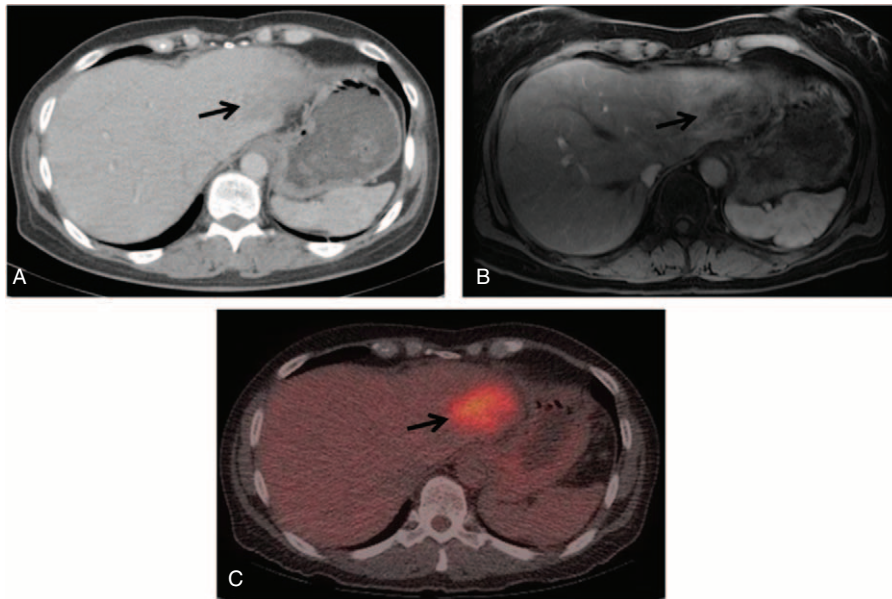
(A) CT, (B) MRI, and (C) PET-CT scans demonstrating lesion in left lateral segment (arrows).
